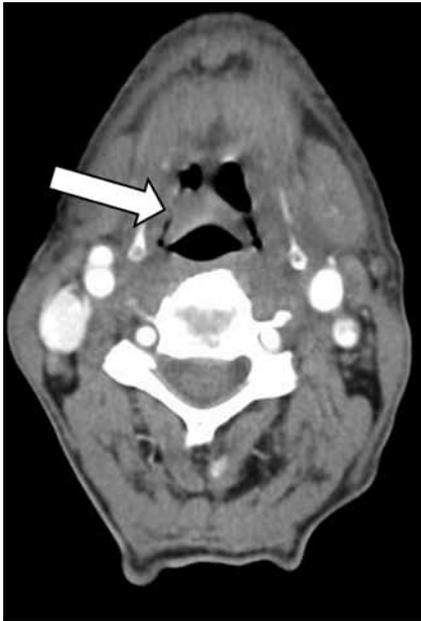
Computed tomography scan of the neck showed bulky epiglottis with ill-defined lesion in its right aspect, ill-defined mass in the left side of supraglottic larynx.
